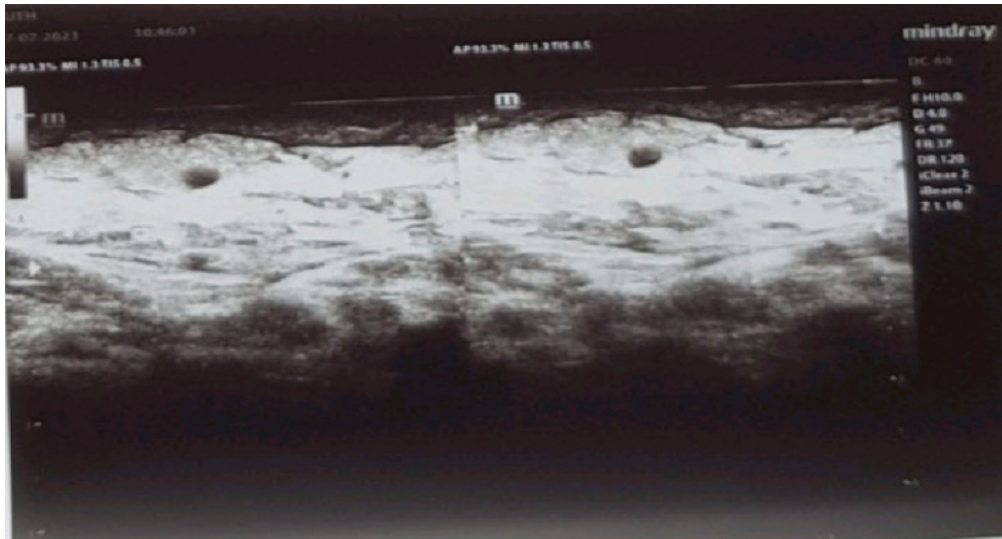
Ultrasound images showing non-compressible vein. Images acquired before (left) and after compression (right)
